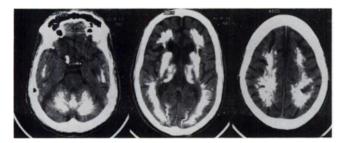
CT scan shows symmetrical calcifications in the basal ganglia, thalamic nuclei, cerebral and cerebellar white matter. Diffuse atrophic changes and ventricular dilatation also are present.
